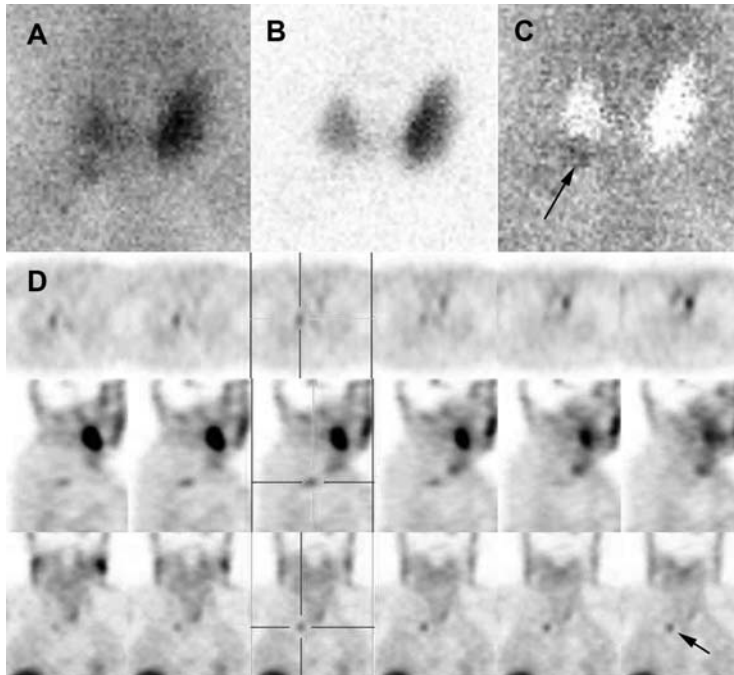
Parathyroid scintigraphy revealed a typical right P4 adenoma. (A) ^{99m}Tc -sestamibi, (B) ^{123}I , (C) subtraction, (D) SPECT images (axial, sagittal, and coronal imaging planes). Planar pinhole subtraction images reveal a focal moderate accumulation of ^{99m}Tc -sestamibi located under the left thyroid lobe (C). SPECT images demonstrate that the gland is prolapsed behind the thyroid gland and is extended posteriorly (black arrows).
